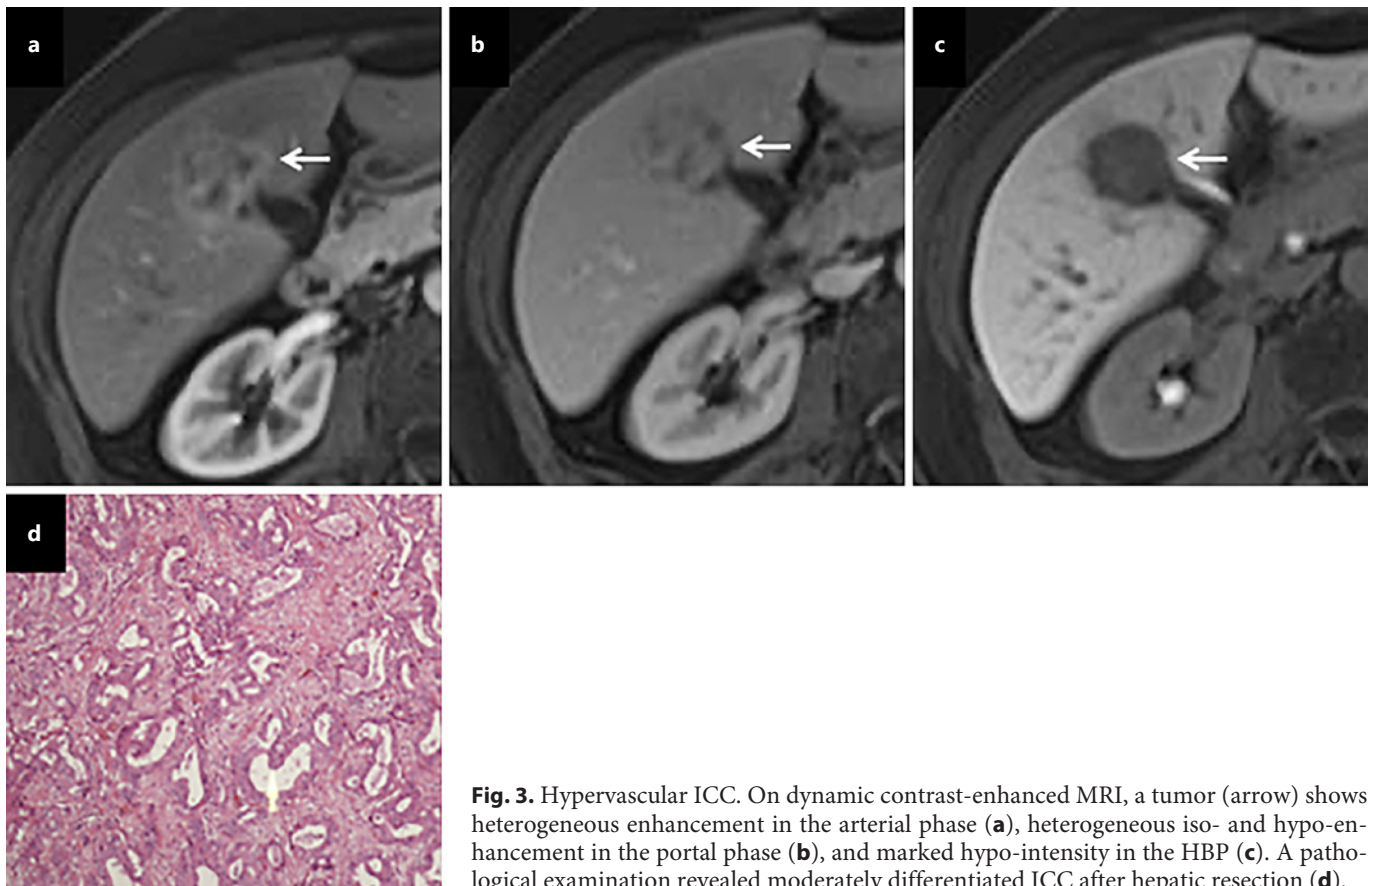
Hypervascular ICC. On dynamic contrast-enhanced MRI, a tumor (arrow) shows heterogeneous enhancement in the arterial phase (a), heterogeneous iso- and hypo-enhancement in the portal phase (b), and marked hypo-intensity in the HBP (c). A pathological examination revealed moderately differentiated ICC after hepatic resection (d).
